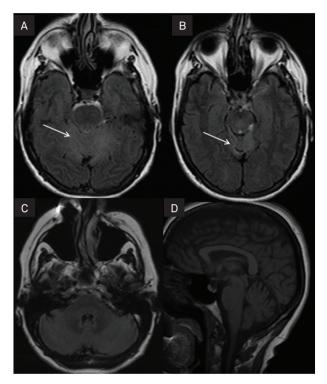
Axial FLAIR-weighted brain magnetic resonance imaging (MRI) disclosed hyperintense sign in the superior cerebellar vermis and upper cerebellar hemispheres (A and B); axial FLAIR and sagittal T1-weighted brain MRI shows no cerebellar atrophy (C and D).
